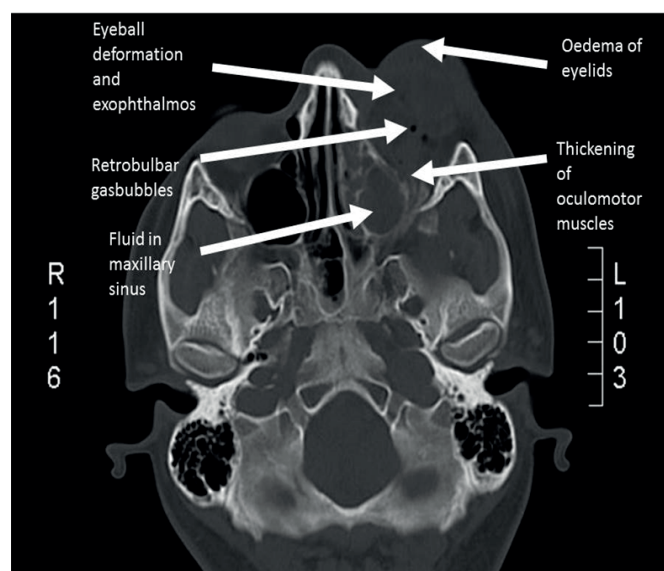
Preoperative computed tomography scan of a patient
